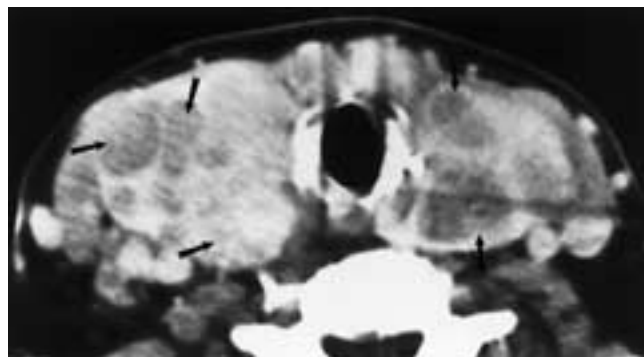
Metastatic renal cell carcinoma to the thyroid gland. Enhanced axial CT scan shows diffuse enlargement of the thyroid gland with multiple hypodense nodules (arrows) consistent with metastatic renal cell carcinoma confirmed pathologically.
